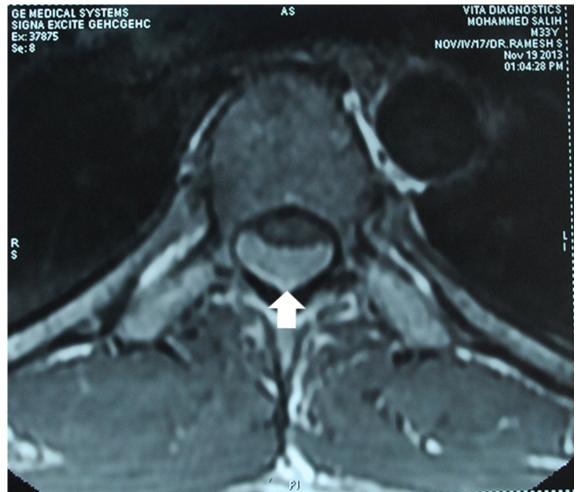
T1 weighted axial MRI of the same lesion
